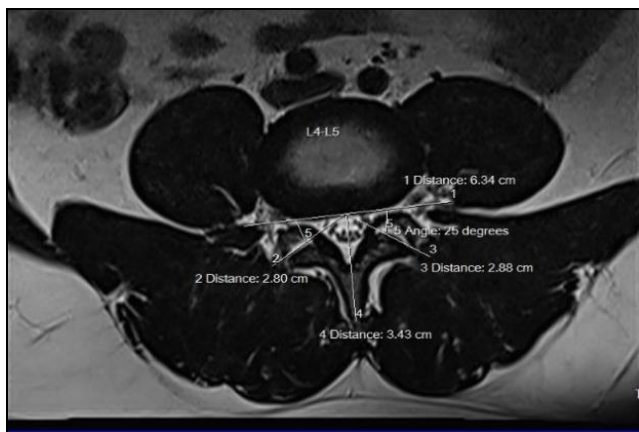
MRI picture: Coronal section where the facet angle is measured
